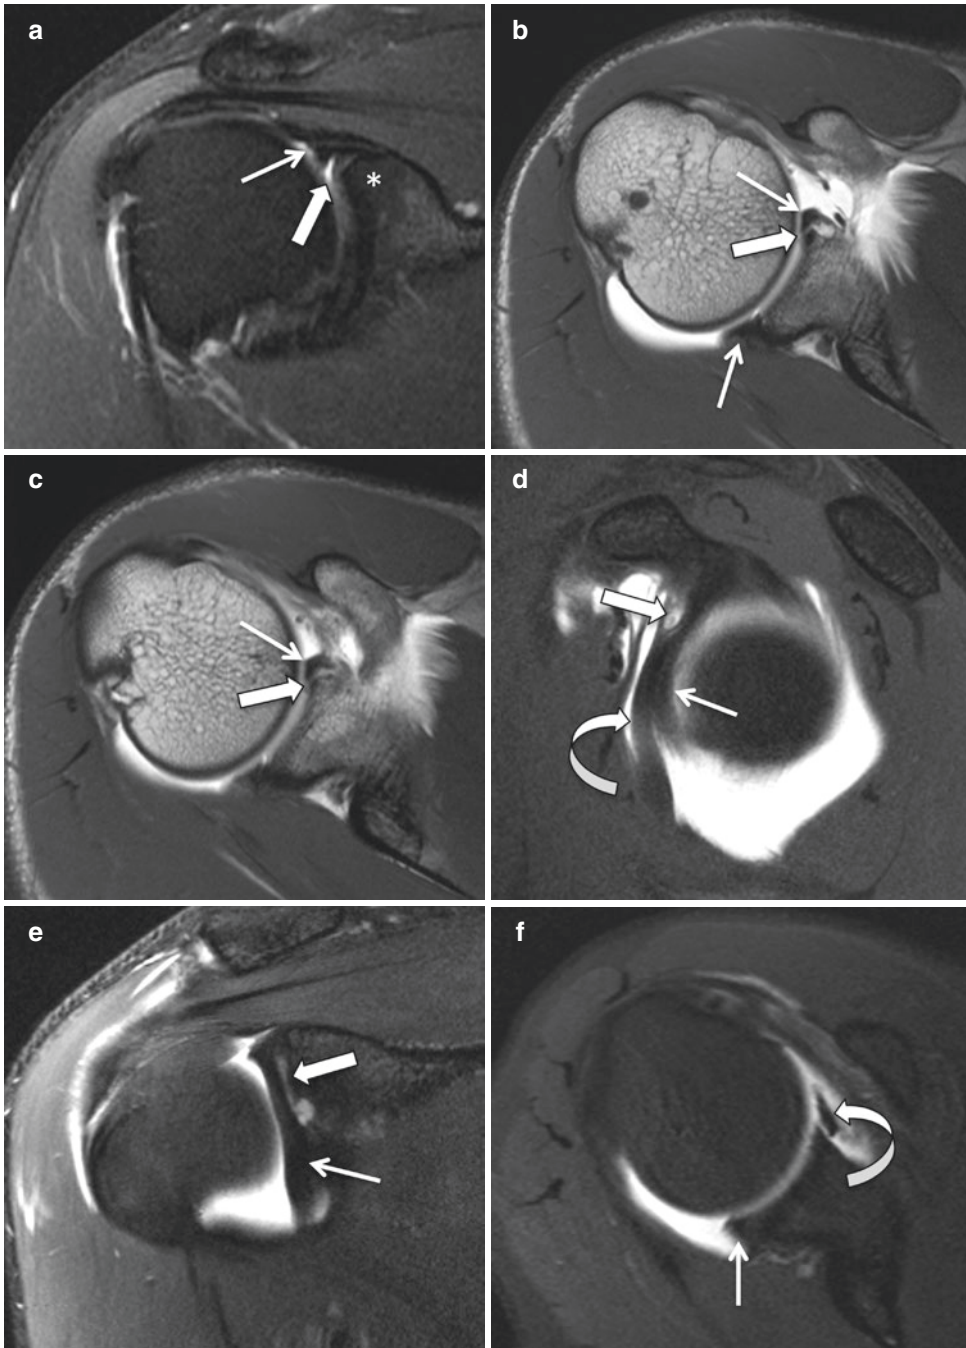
Sublabral recess, sublabral foramen, and Buford complex. (a) Coronal fat-saturated T2-weighted MR image showing a fluid-filled sublabral recess (thick arrow) between the superior glenoid rim (asterisk) and the biceps-labral complex (thin arrow). Axial nonfat-saturated T1-weighted (b and c), sagittal fat-saturated T1-weighted (d), and coronal fat-saturated T2-weighted (e) arthrographic MR images demonstrating a sublabral foramen
